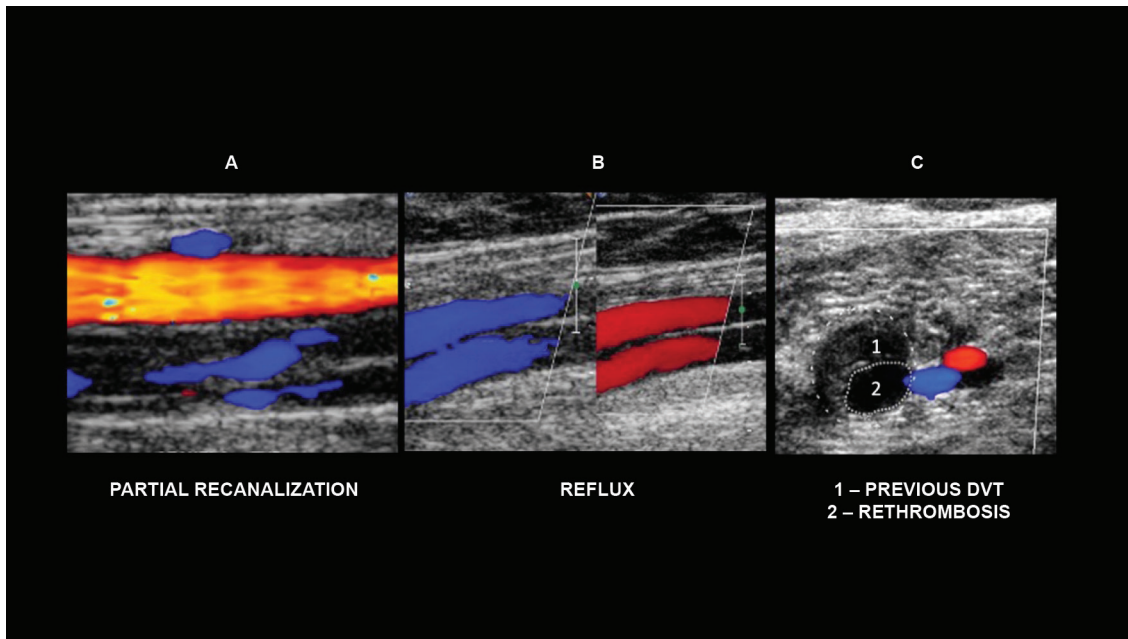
Ultrasound changes that may be found in the follow-up of patients with deep vein thrombosis. A: longitudinal view of the femoral artery (red) and femoral vein (blue). Presence of partial recanalization of the venous segment surrounding residual fibrosis. B: longitudinal view of the femoral vein. Normal ascending venous flow is detected in blue by color flow Doppler, and reflux is shown in red after distal compression maneuver. C: cross-sectional view of the calf muscle vein, with increased diameters and reduced compressibility. In 1, an echogenic image refers to a previous DVT, and in 2, a hypoechoic image refers to a current recurrence.
